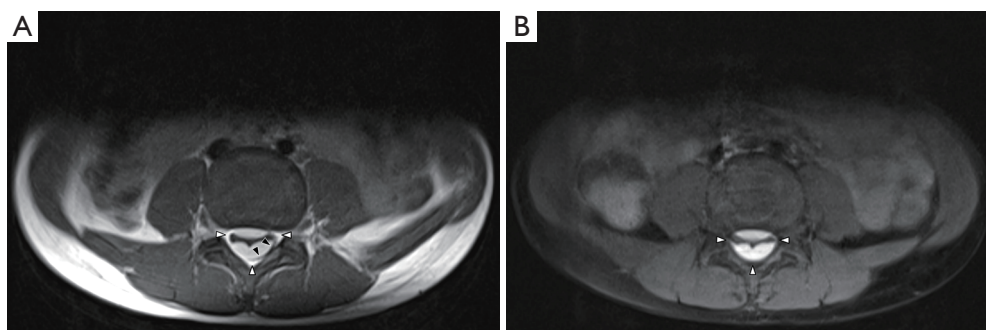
Axial (A) T1-weighted and (B) fat-saturated T1-weighted sequences of the lumbar spine. On the T1-weighted sequence, the thin hypointense dura (black arrowheads) is outlined between the hyperintense collection and epidural fat (white arrowheads). On the fat-saturated T1 sequence, the epidural fat suppresses but the collection remains bright, confirming the presence of blood.
